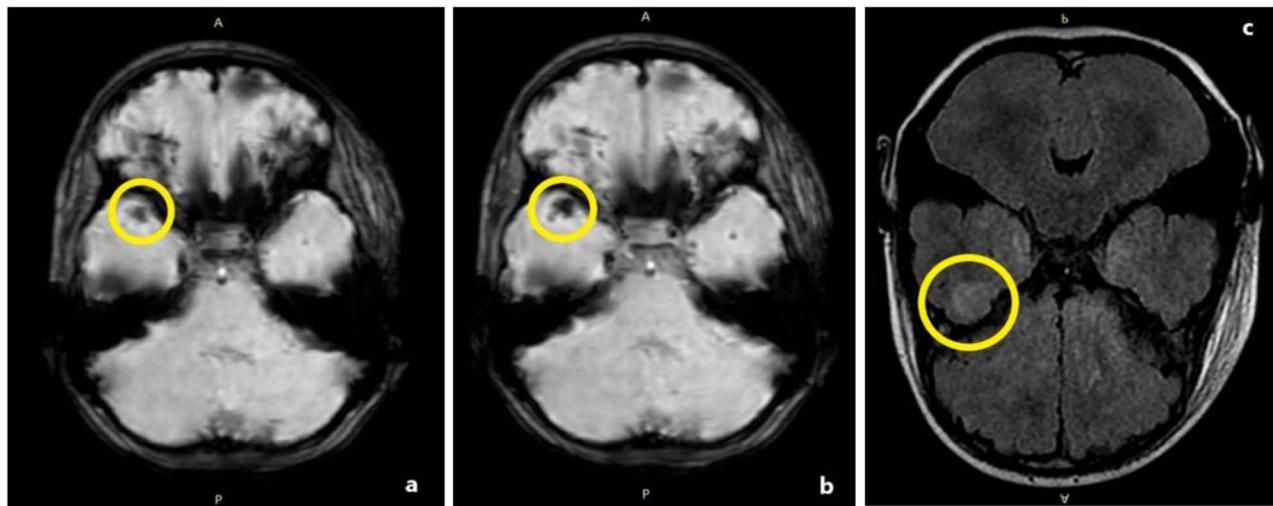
An 8-year-old pedestrian girl was involved in a motor vehicle accident. (a and b) Eighteen hours after admission, an MRI was performed. Hemorrhagic CC in the anterior part of the right temporal lobe appears as an area of hypointense SWI signal (yellow circle). (c) corresponding FLAIR signal imaging at the same level, showcasing hyperintense cortical (yellow circle).
